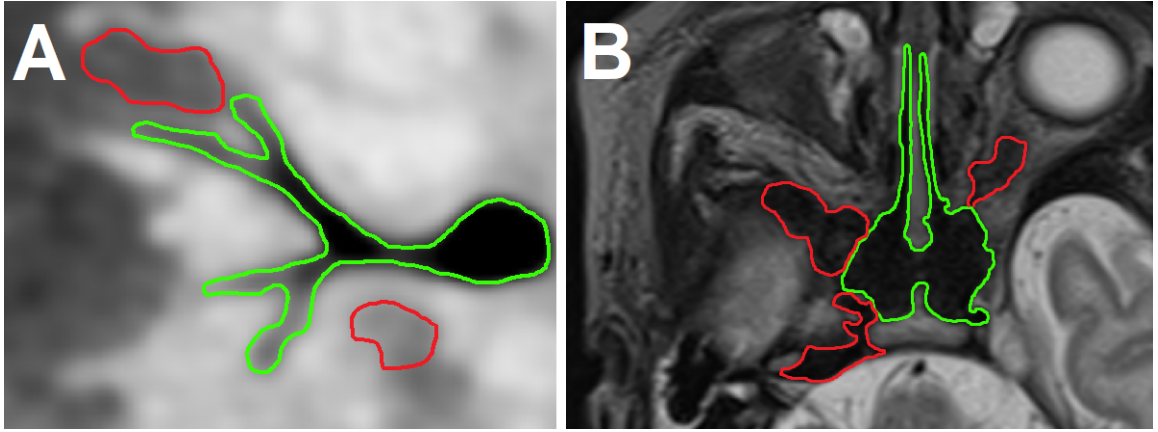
Segmented airways: Green line - valid segmentation, Red line - Tissues or cavities which does not belong to the airways, but has similar intensity values. (A) Transversal view of lungs CT scan, (B) transversal view MRI head scan.
